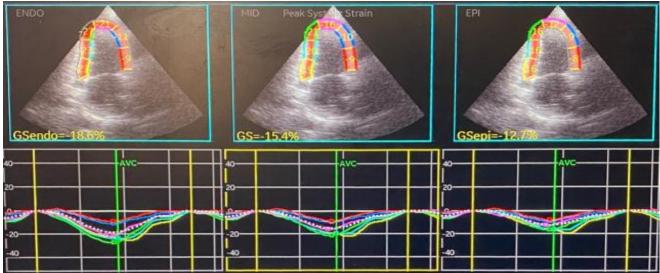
2D-STE measurement of global LSS in apical 2-chamber view in a hypertensive patient with strain, the quantitative strain measurements of the endocardium GSendo (-18.6), middle GSmid (-15.4), and epicardium GSepi (-12.7).
